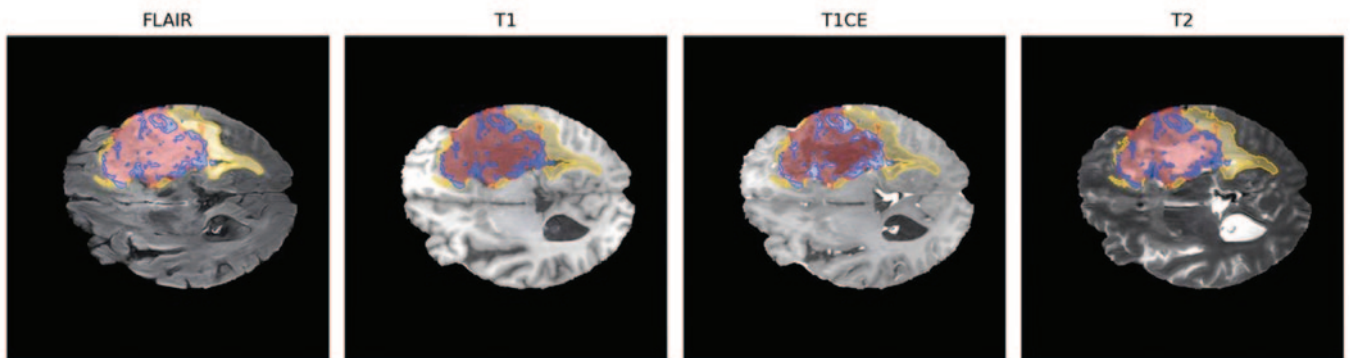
MRI of a patient with a glioblastoma imaged in four modalities: FLAIR; T1; T1 contrast-enhanced (T1CE); and, T2. Red represents the tumour core, blue represents enhancing tumour regions, and yellow represents the surrounding oedema. Image reproduced from the BraTS 2020 dataset under CC BY 4.0.^{12,13,46,47}
